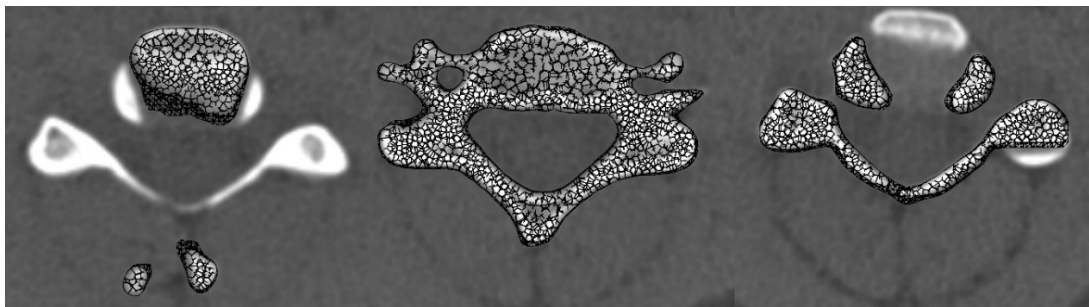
Three slices at different heights of the Z-axis of the generated structure and their relation to CT scans at the same height in the bone are presented.
